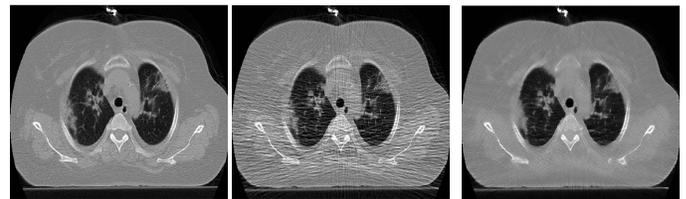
Transvers views of full-dose, low-dose and predicted full-dose CT images for an outlier case from left to right, respectively.
